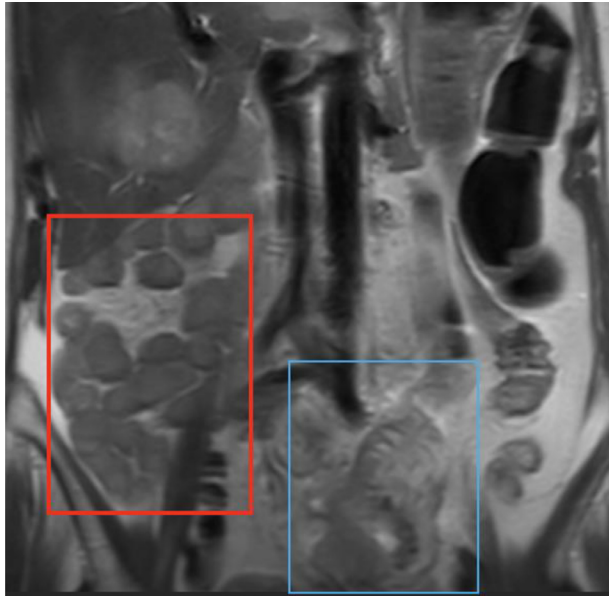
Coronal T2 MRI sequence showing an exclusive distribution of the intestines on the right side (red square), with the colon positioned on the left (blue square).
